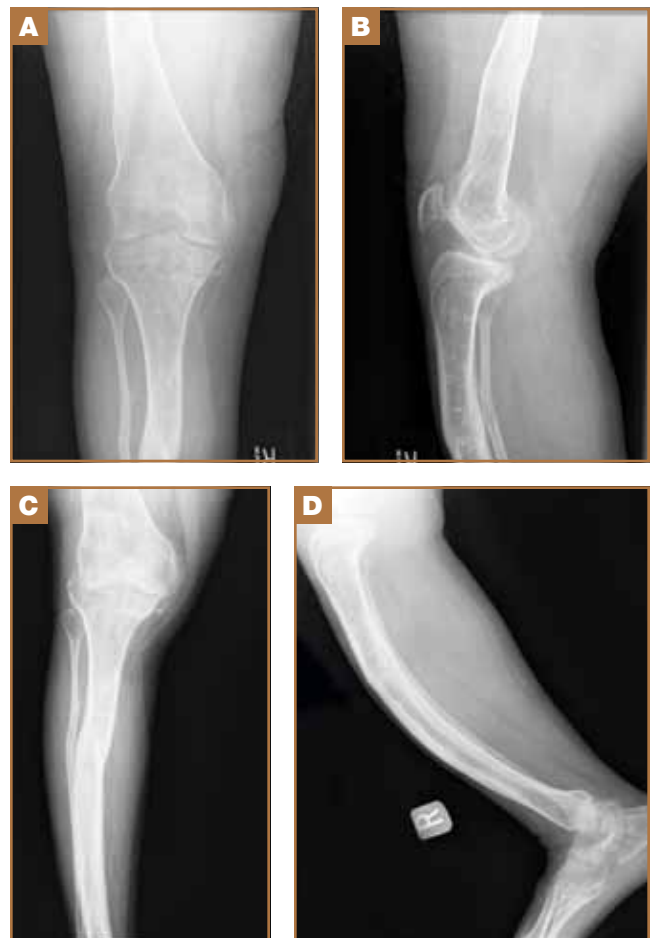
AP and lateral radiographs of the right knee (A, B) and right tibia (C, D).
